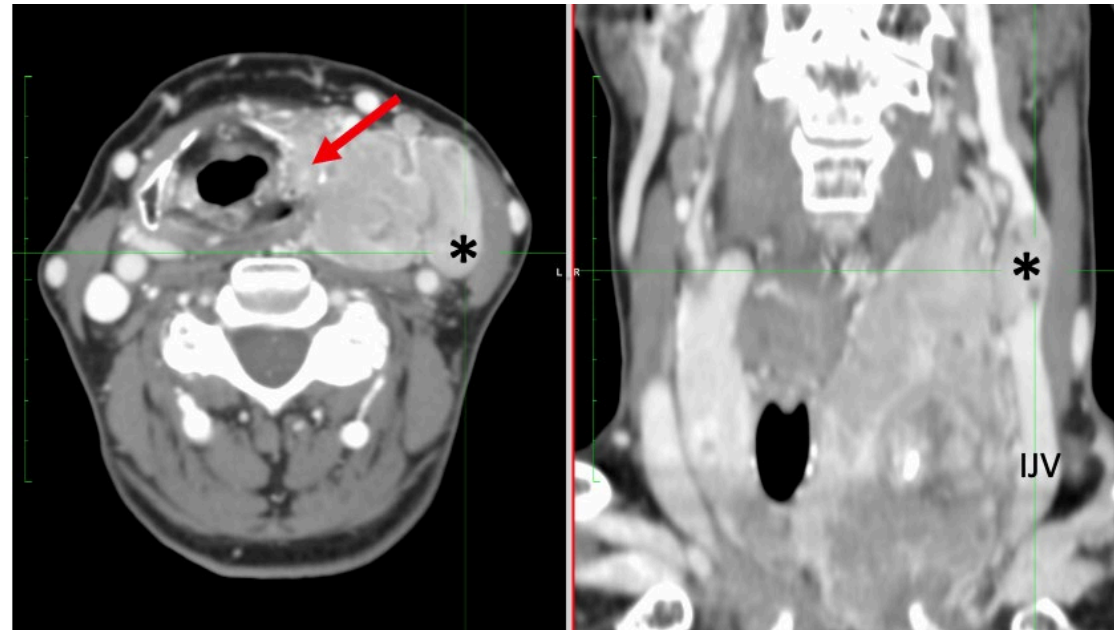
Contrast-enhanced CT scan showing an invasive cervical mass developed from left thyroid lobe. The lesion invades thyroid cartilage (arrow) and left larynx and extends into the ipsilateral jugular vein. Intravenous tumour thrombus (asterisks). IJV = internal jugular vein.
